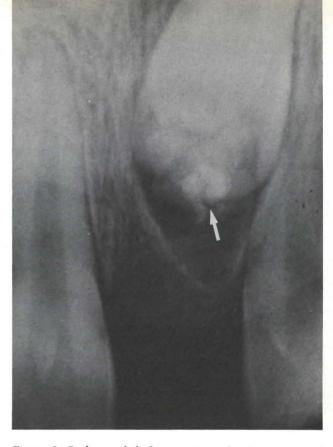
Radiograph before surgery, showing unerupted maxillary left central incisor and associated odontome.
